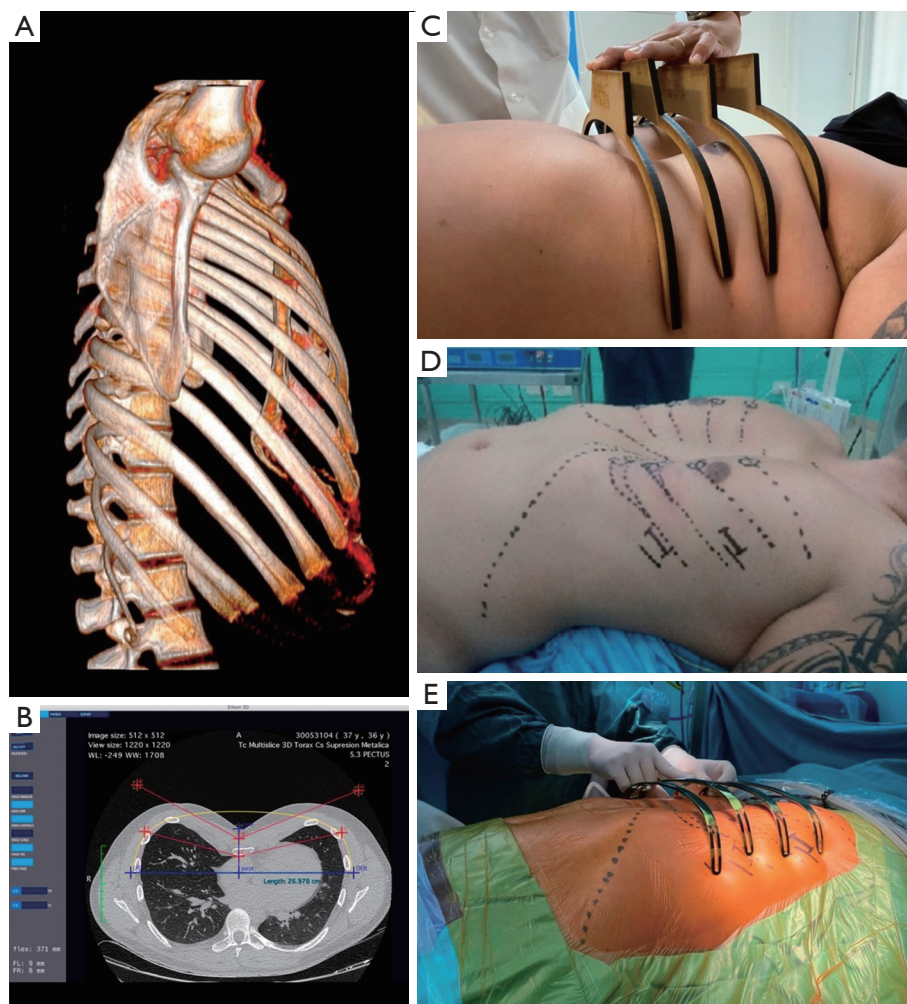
The preoperative planning of our patients undergoing minimally invasive repair of pectus excavatum is comprised of several steps. (A) Chest wall 3D virtual reconstruction from a CT; (B) virtual implant design using a semiautomatic software (Erkom 3D Chest Wall Pro 1.3, Pampamed, Buenos Aires, Argentina) that was specifically developed for this purpose; (C) during a dedicated fitting session at the outpatient clinic, 3D printed, customized, poly-lactic acid templates are checked on the patients' chest wall; (D) marking of the patient showing the intercostal spaces, as well as the implants' entry and exit points of the thoracic cavity; (E) final trial of the implants in the operation room. 3D, three-dimensional; CT, computed tomography.
